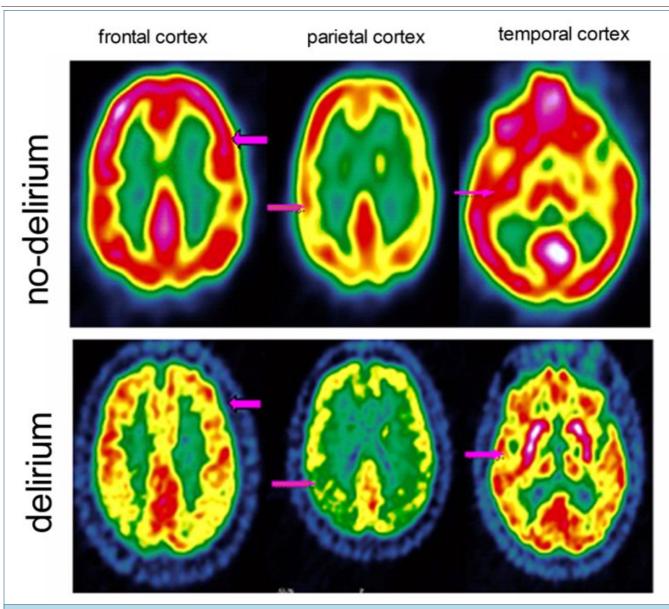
Representative PET/CT Brain Images of Patients with and without Postoperative Delirium. Representative PET/CT brain images of patients with and without postoperative delirium. Images were obtained after patients received intravenous 18F FDG. The different colors represent levels of glucose metabolism, with red denoting the highest, green the lowest, and yellow intermediate levels. The higher intensities of redness suggest higher glucose metabolism levels; and the greener the color, the lower the glucose metabolism.
